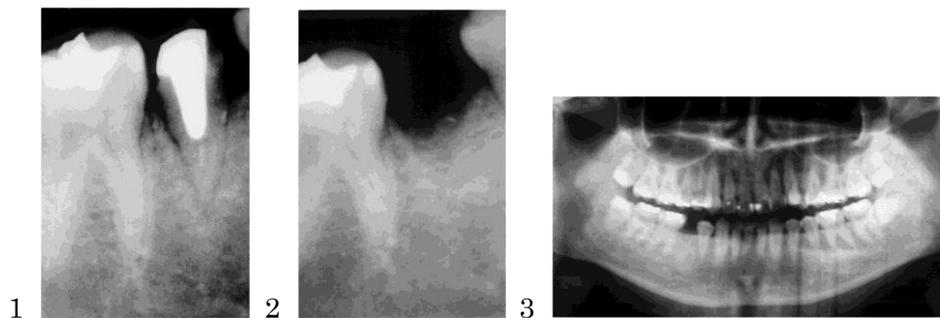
Dental radiograph at the first medical examination.
